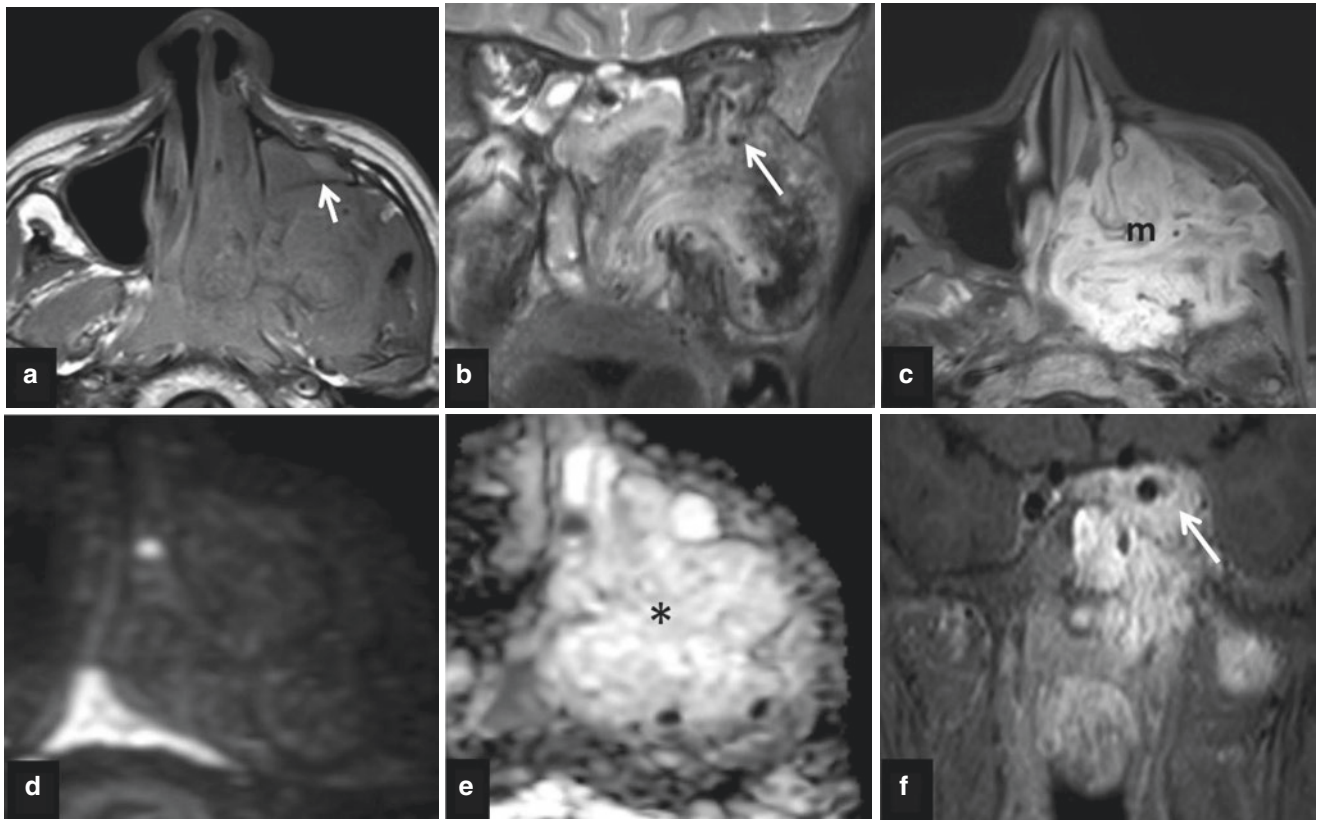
(a–f) Sinonasal tract angiofibroma (Stage III) MRI. (a) Bowing of posterior antral wall (arrow); (b) Intermediate signal intensity with flow voids on T2 WI (arrow). (c) Intense post-contrast enhancement in the mass (m); (d, e) Facilitated diffusion—bright on
